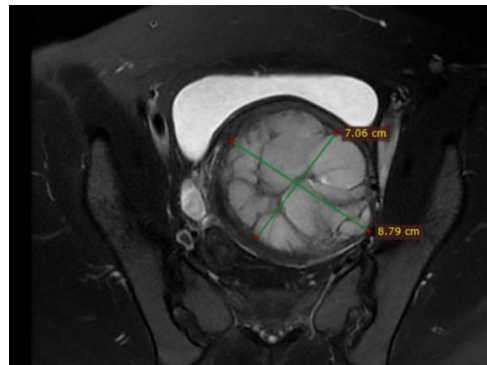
MRI revealed a tumor of about 9 cm
